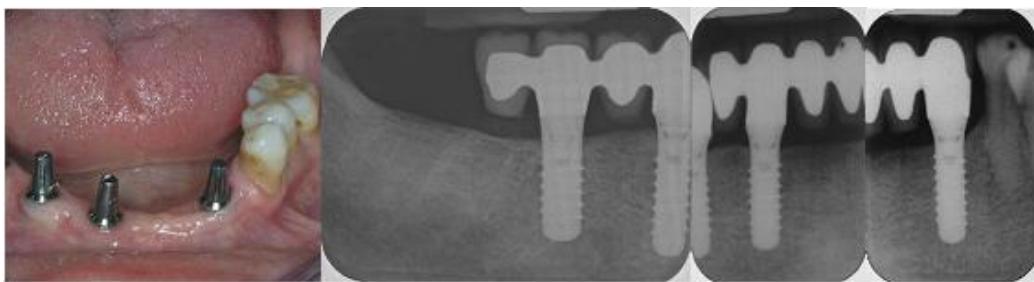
Cantilever designs used in implant supported fixed prostheses to optimize implant number (a) in treatment of mandibular long span edentulism, and their 10-year radiographic follow-up (b to d).
